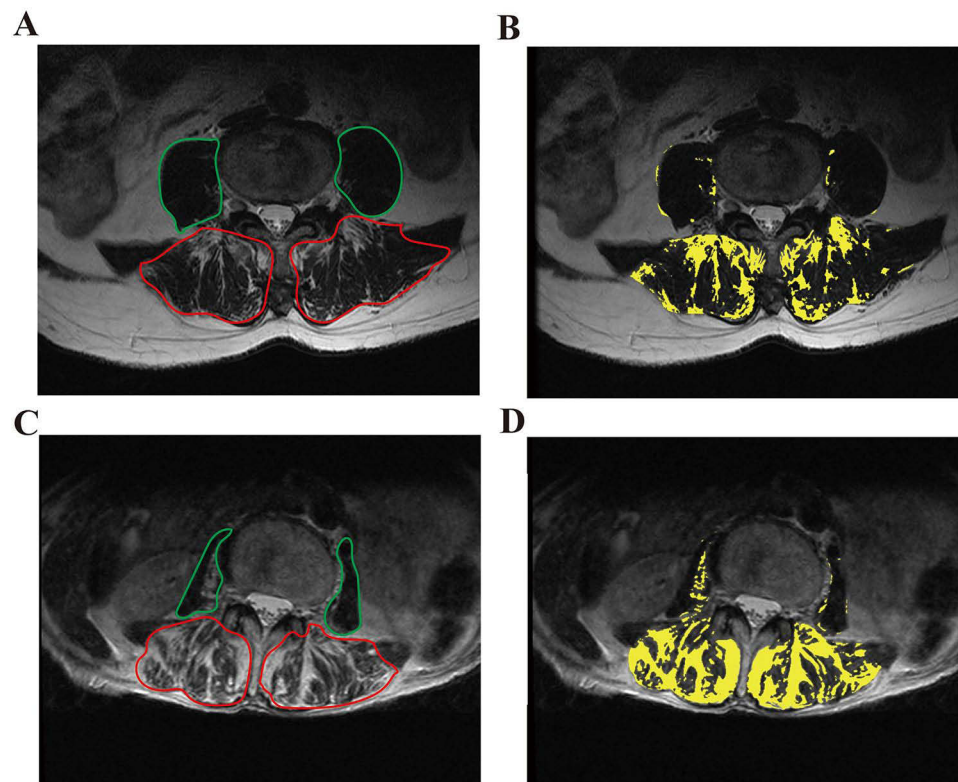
Transverse section of lumbar MRI at the L4 level of a 65-year-old female patient (A and B) demonstrating a total psoas major (PS) area (A, green) of 14.41 cm² and fat infiltration (B, yellow) percentage (FI%) of 33.24% in the erector spinae (ES) and multifidus (MF) muscles (A, red). Transverse section of lumbar MRI at the L4 level of a 69-year-old female patient (C and D) with reduced total PS (C, green) area (8.71 cm²) and elevated FI% (D, yellow) (74.75%) in the ES and MF muscles (C, red).
